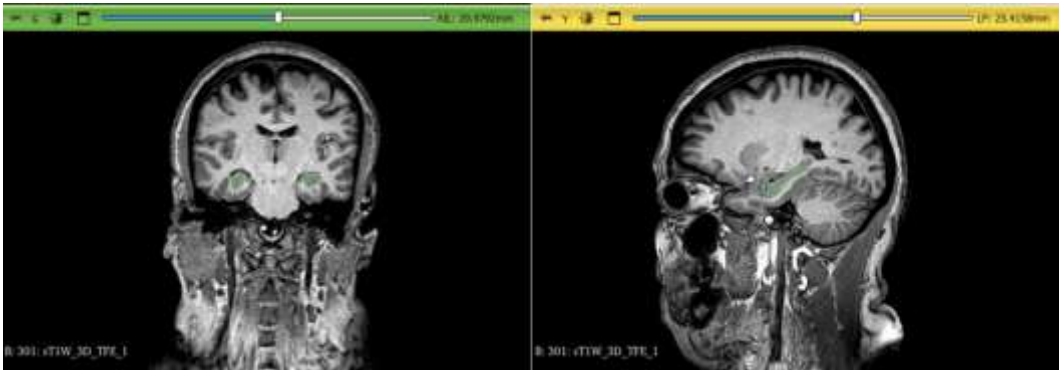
Coronal and sagittal T1-weighted MRI image manual measurement.
